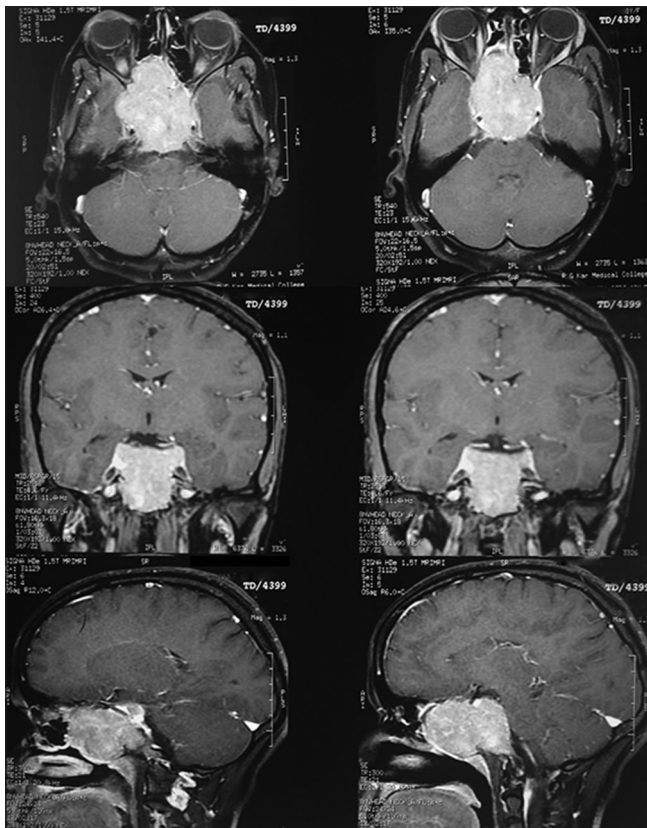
Magnetic resonance image
